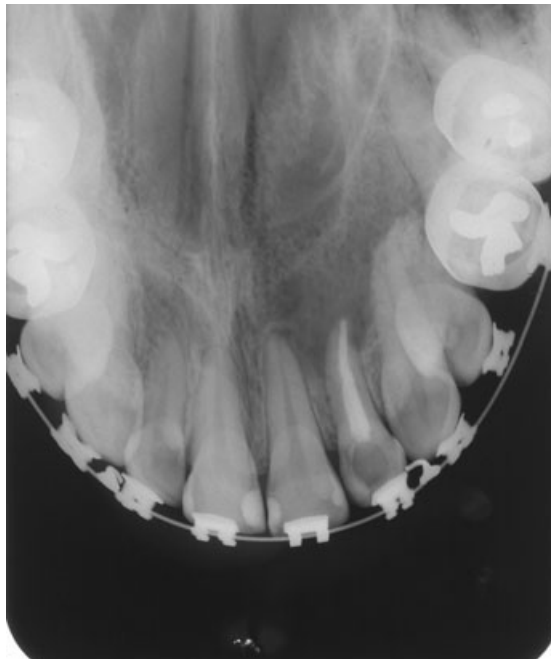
Advanced periapical bone repair at 14 months after root canal filling.
